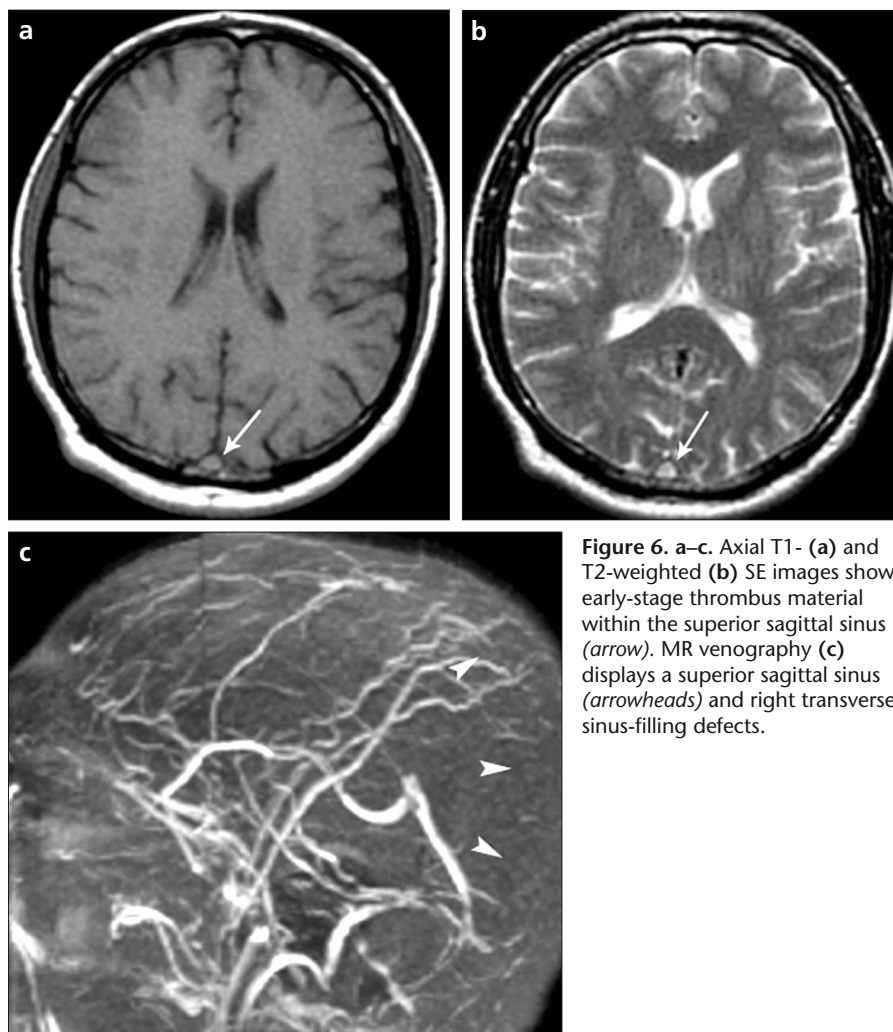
a–c. Axial T1- (a) and T2-weighted (b) SE images show early-stage thrombus material within the superior sagittal sinus (arrow). MR venography (c) displays a superior sagittal sinus (arrowheads) and right transverse sinus-filling defects.
